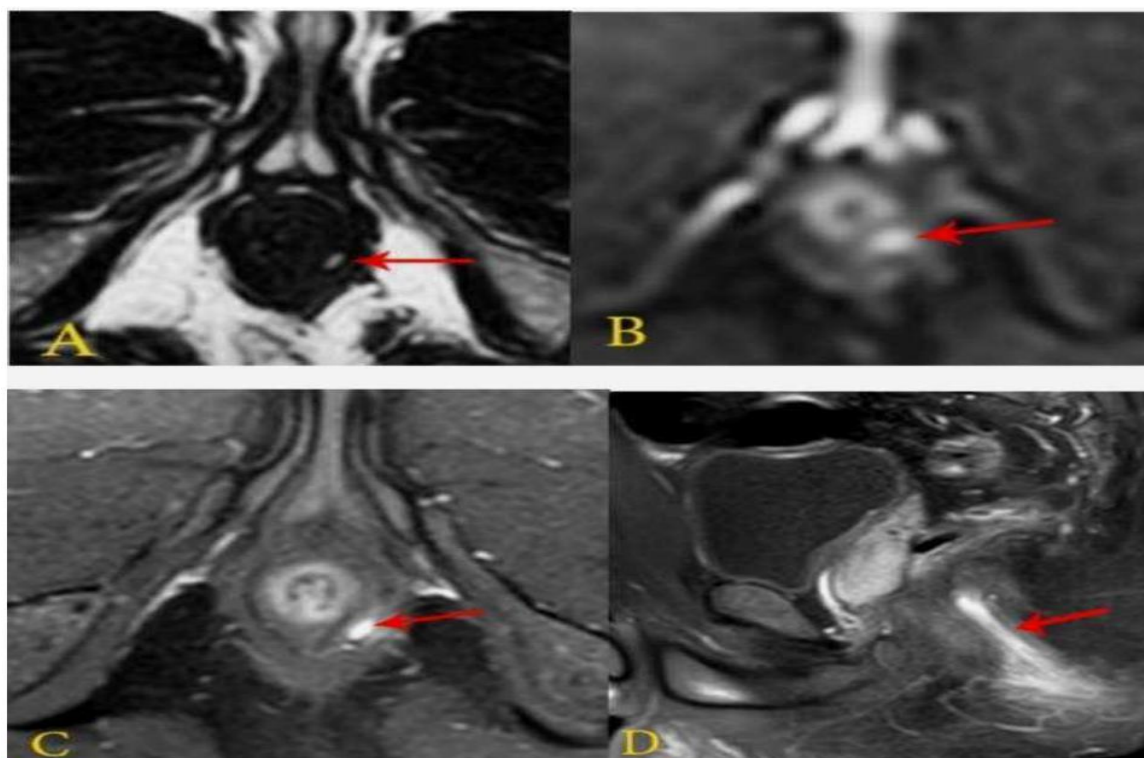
A male patient aged 36 years old with continuous anal pain, and pruritus. (A) Axial T2WI: shows fistula tract (arrow) that exhibits slightly high SI opens at 4 o'clock position.(B) Axial DWI shows restricted diffusion (hyper-intensity) of more pronounced trans-sphincteric fistula (C,D) Axial and sagittal fat-suppressed T1+C: enhanced linear non -branching fistulous tract.Overall MRI finding consistent with trans-sphincteric fistula (Grade III).
